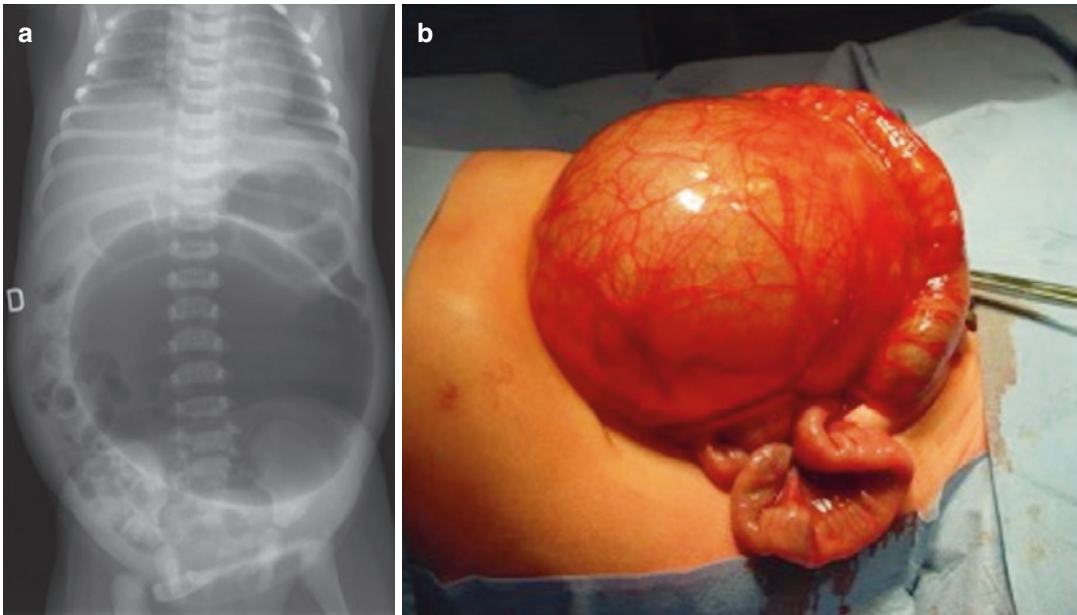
Acute neonatal distension of a communicating duplication cyst. (a) Abdominal radiograph showing a large distended digestive structure, which corresponds to an acute aeration of a communicating duplication cyst. (b) Surgery confirms the presence of a distended duplication cyst (Courtesy P. Lingier MD)
